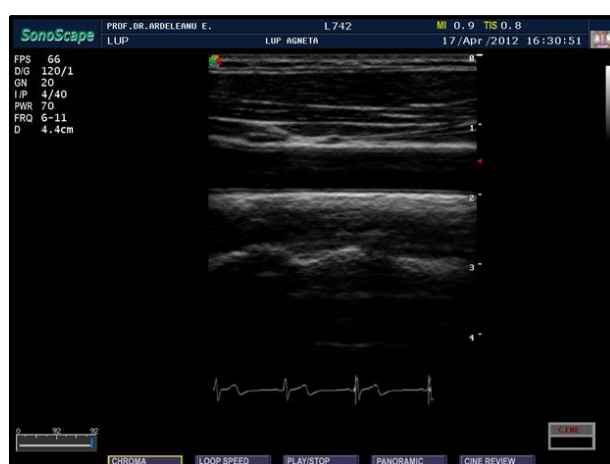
B-mode ultrasound. CIMT is seen as a double echogenic line at the far wall of the CCA
